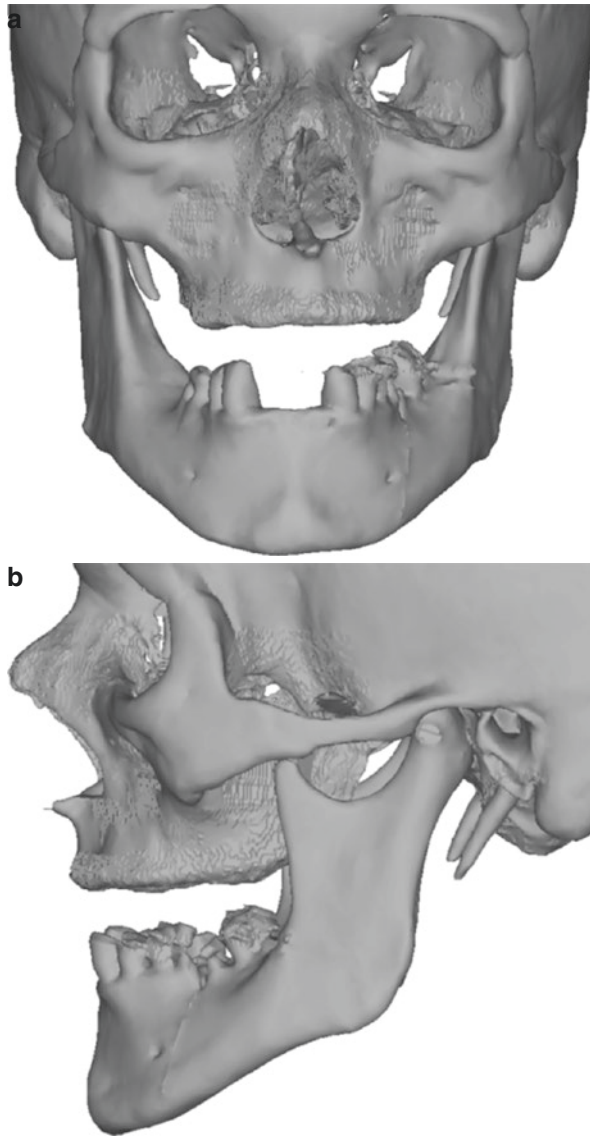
Stages of the virtual surgical planning process for a patient with chronic bilateral TMJ dislocation treated with bilateral total joint replacement prostheses: (a) 3D CT scan frontal view, (b) 3D CT scan left lateral view, (c) cast stone model of the patient's upper denture laser scanned into the 3D CT scan to provide occlusal detail and preservation of the occlusal height, (d) in situ upper and lower occlusal splints designed and manufactured using VSP, (e) in situ mandibular cutting guide designed and manufactured using VSP, (f) upper and lower occlusal splints with locating countersinks (separated), (g) upper and lower occlusal splints with locating countersinks (engaged)
